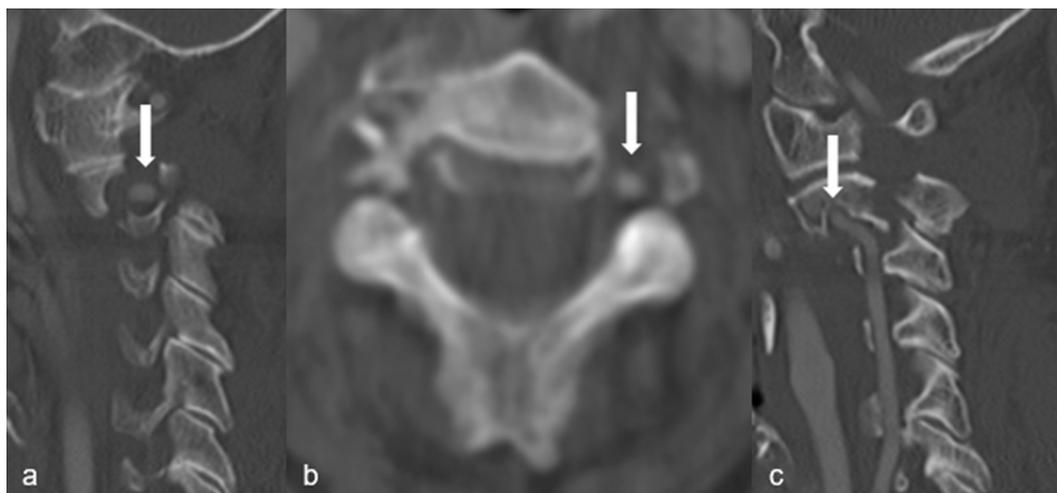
CT-angiography of Case 1 in (a) sagittal and (b) axial view, with the arrow pointing at the vertebral artery running inside the fracture gap and (c) sagittal view of the high riding right vertebral artery, indicated by the arrow.
